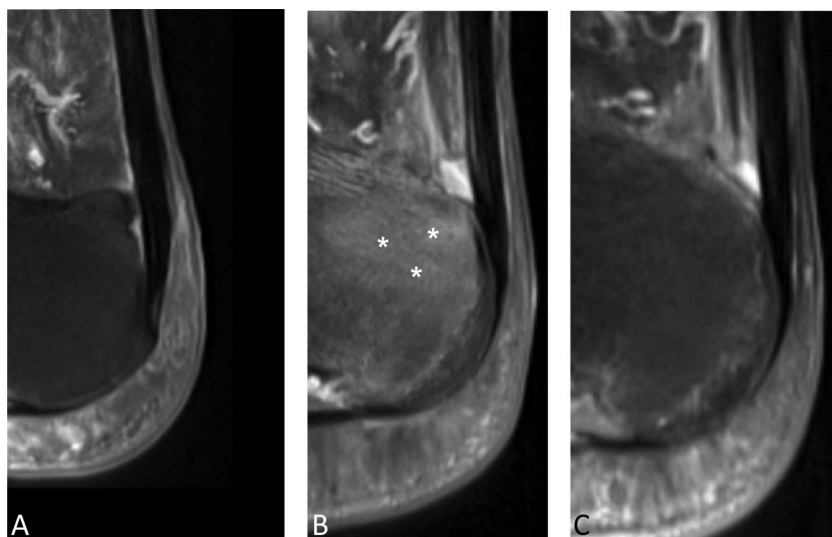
Preoperative and postoperative images from calcaneus near the Achilles tendon insertion: (A) preoperative (T2-image on MRI); (B) the onset of sharp pain at 4-month postoperative (T2-image on MRI, *); and (C) resolution of CBB (T2-image on MRI) at 7-month postoperative.
